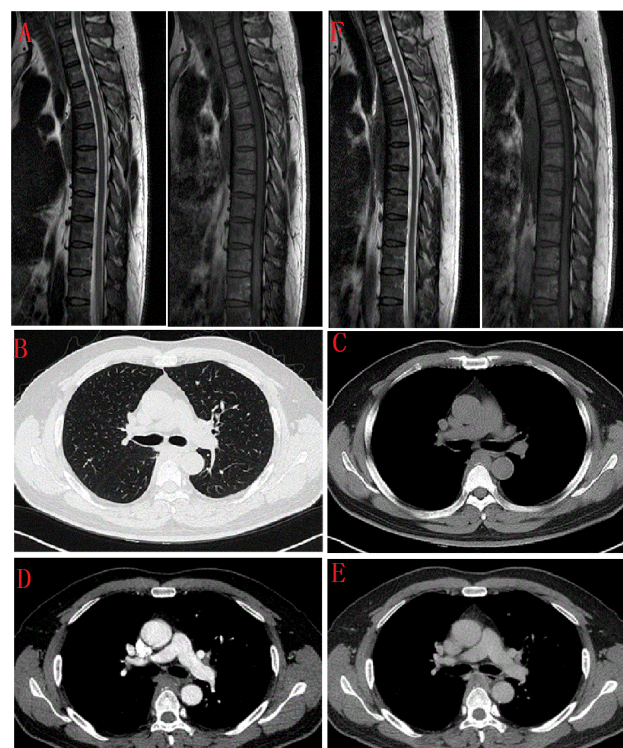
The first sagittal spinal column MRI scan of T2WI and T1WI image (A). In the chest CECT scan, the lung and mediastinal windows of plain scan images (B and C). In the chest CECT scan, the enhanced images (D and E). The second follow-up sagittal spinal column MRI scan (F).
